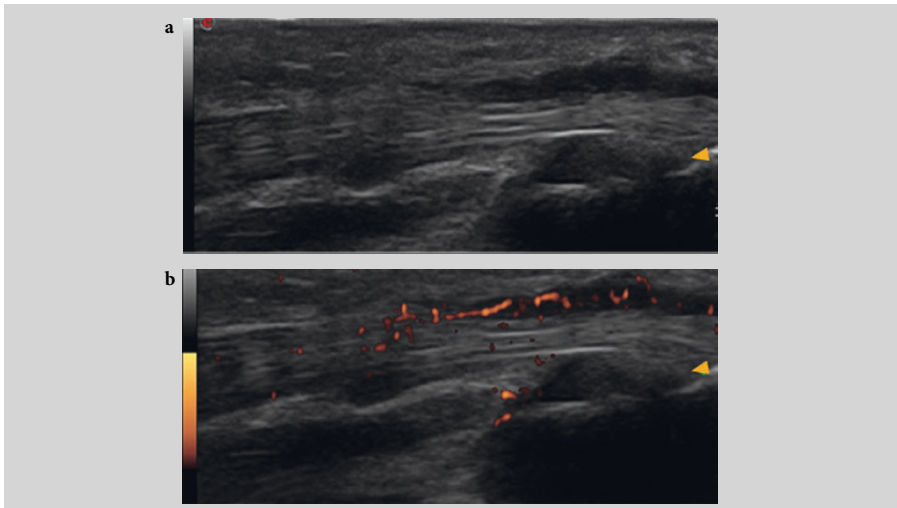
Ultrasound longitudinal scan of extensor ulnaris carpi. (a) Minimal tenosynovitis in grayscale. (b) Minimal tenosynovitis with power Doppler signal within tendon sheet.
